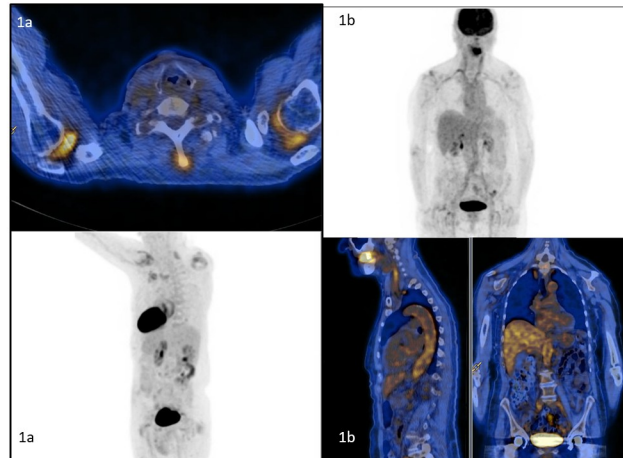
^{18}F FDG-PET/CT images. 1A: Uptake in shoulders and cervical interspinous bursae. 1B: Uptake in supra- and infra-diaphragmatic aorta.
